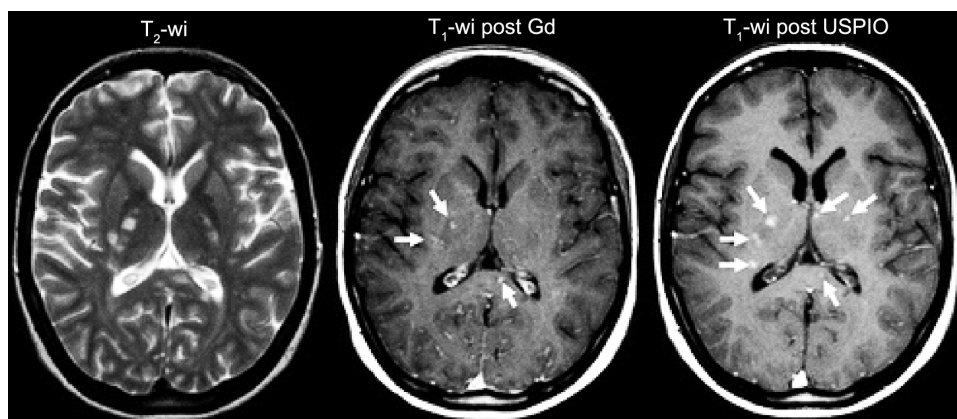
Discrepancies are present in lesion visualization between Gd-enhanced MRI (for BBB breakdown) and USPIO MRI (for macrophage accumulation). More lesions are observed with USPIO MRI (white arrows) as compared to Gd MRI (white arrows). Figure adapted and reproduced with permission from Ref. 115.
